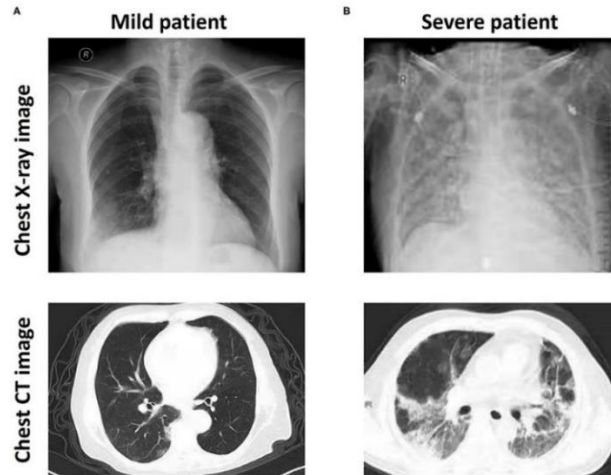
CXR and CT images with mild (A) and severe (B) COVID-19 [24].
